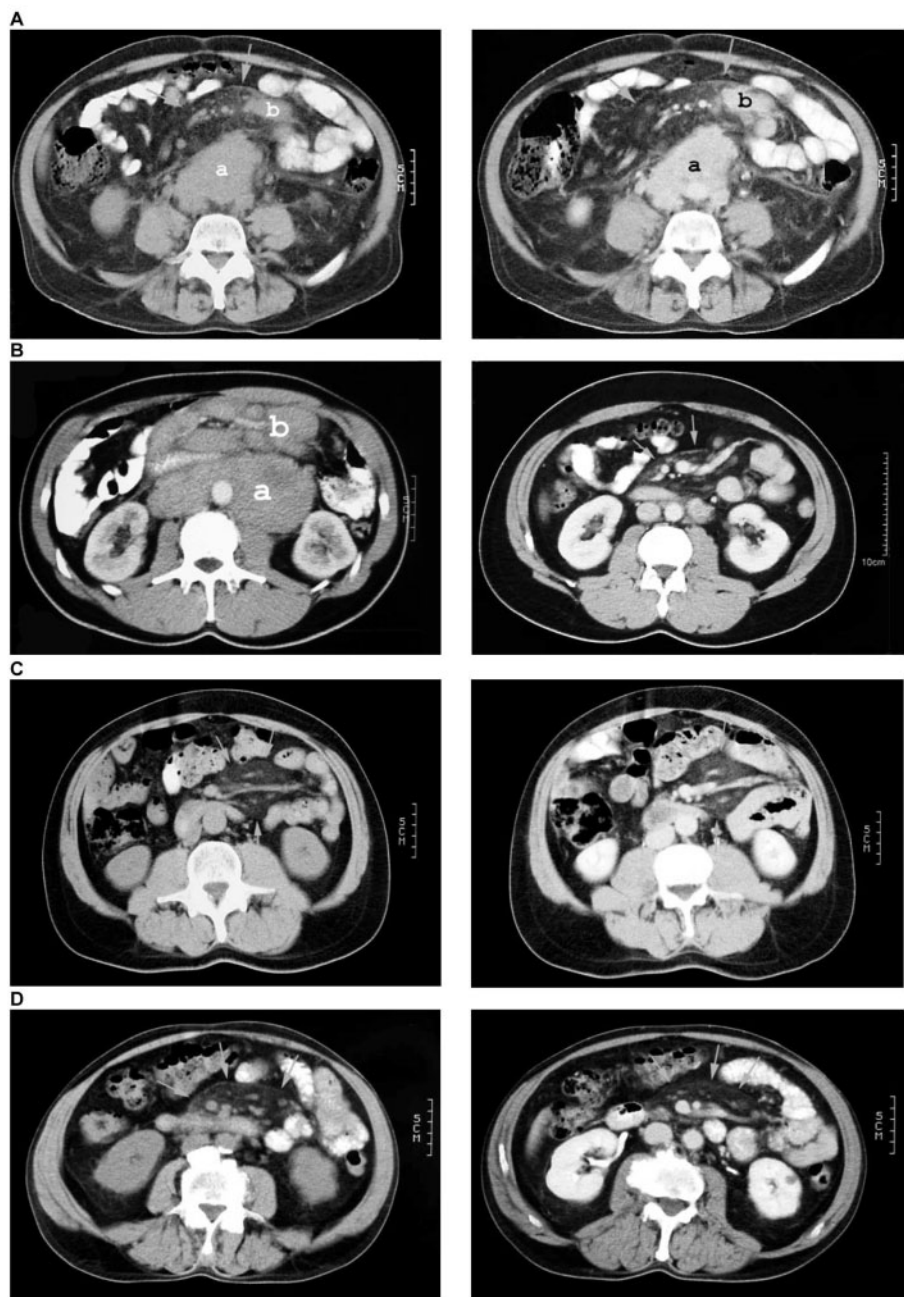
A Extensive retroperitoneal (a) and mesenteric (b) lymphoma with additional mesenteric alterations (higher density compared to surrounding fat tissue, arrows) (native CT scan left, intravenous (iv) contrast right). B Extensive retroperitoneal (a) and mesenteric (b) lymphoma (iv contrast left) with near complete remission and remaining mesenteric alterations (arrows) (iv contrast right). C Mesenteric alterations in a patient with extraabdominal lymphoma (arrows) (native CT scan left, iv contrast right). D Mesenteric alterations in a patient with adenocarcinoma of the colon (native CT scan left, iv contrast right).
